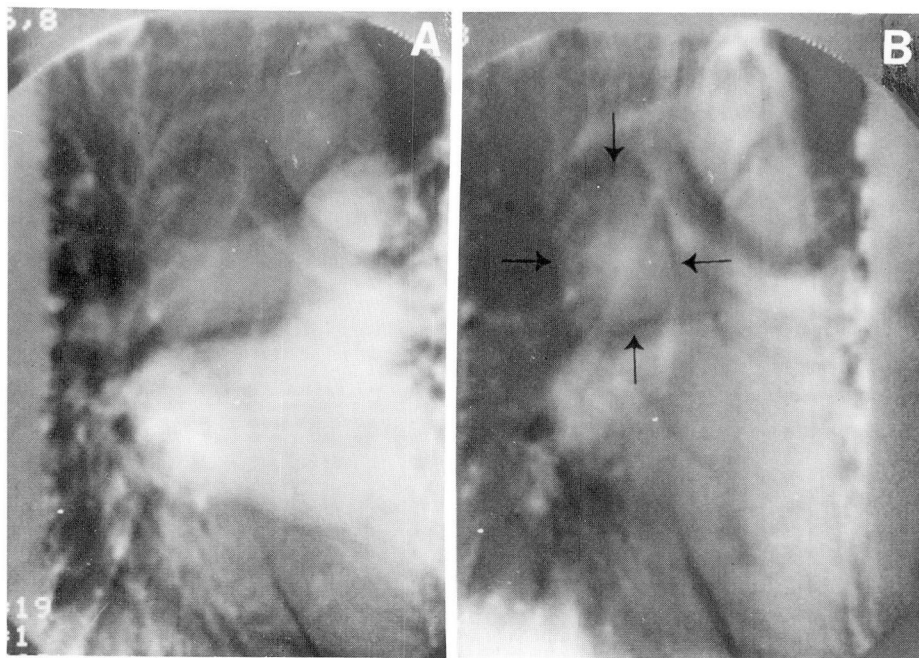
Early (A) and late (B) phase of DSA of the chest after 40 ml 76% contrast medium to the basilic vein of the right arm. Retained contrast agent identifies a mass in the right side of the anterior mediastinum (arrows), in the same position as the mass identified on CT (Fig. 1).
